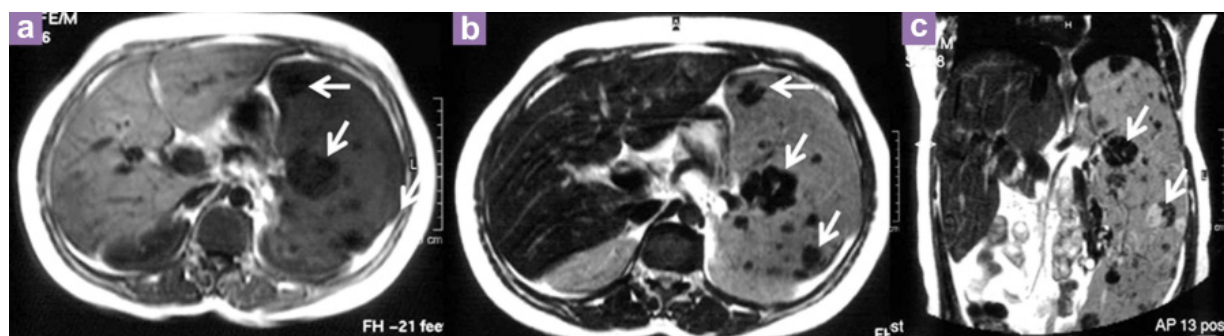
Axial (a,b) and coronal (c) abdominopelvic magnetic resonance imaging of a 46-year-old woman with Gaucher's disease and hepatosplenomegaly. Many splenic nodules (white arrows) exhibit low signal intensity on axial T1-WI, and most have low signal intensity on axial T2-WI and coronal T2-WI.
